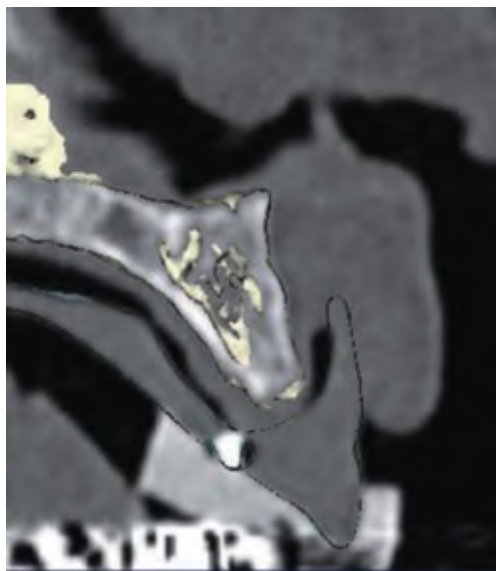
This is a cross-sectional oblique slice of the reformatted computed tomography scan in Figure 1.24. This view allowed the surgeon and prosthodontist to precisely identify the amount of bone available for implant placement and how the planned site related to the location of the teeth in the prosthesis.
